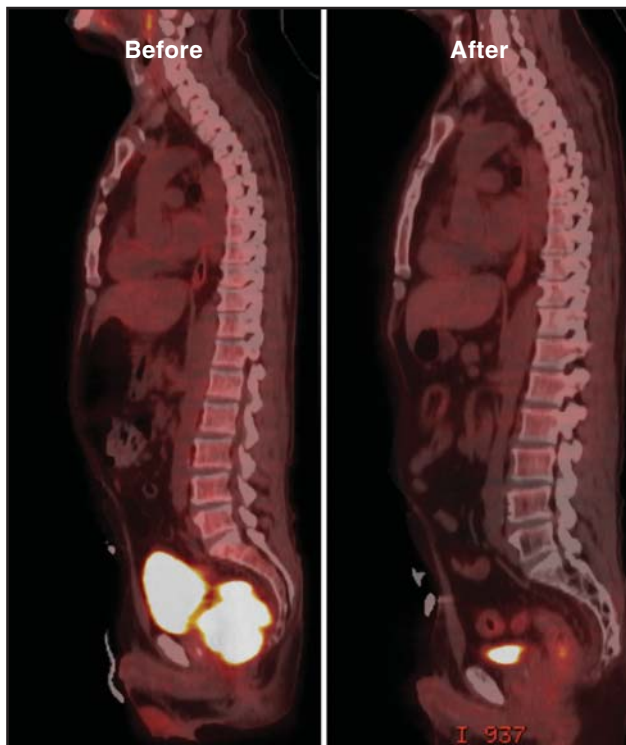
PET CT showing excellent response to preoperative chemoradiation with near complete resolution of uptake of tumor posterior to the bladder.
